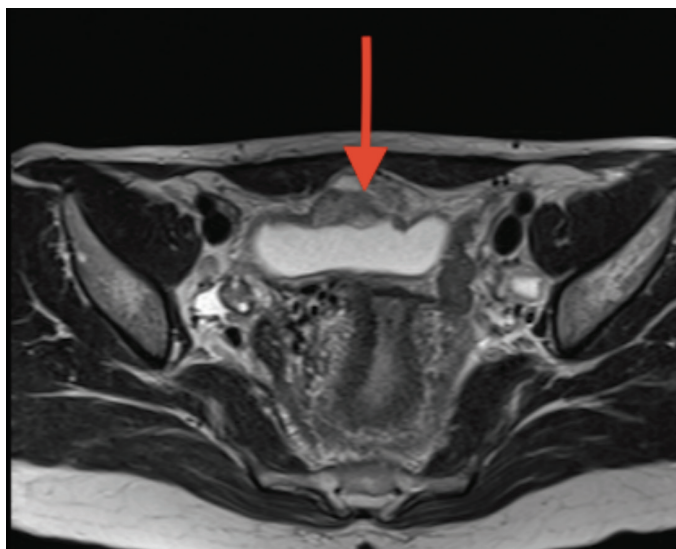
MRI showing a 5x6 cm diameter mass, which originates from the anterosuperior part of the bladder
